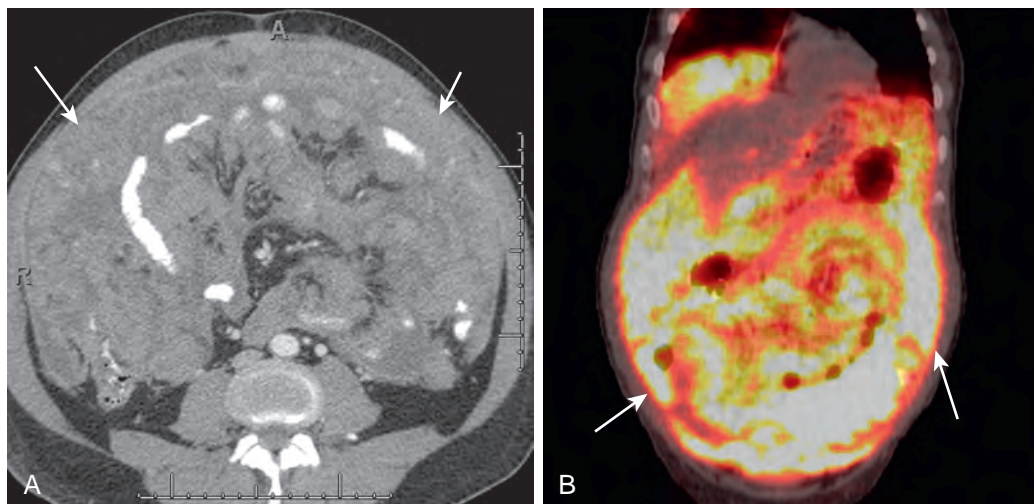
Peritoneal lymphomatosis. Axial CT (A) and coronal PET/CT (B) demonstrate peritoneal lymphomatosis (arrows). The imaging appearance is similar to that of peritoneal carcinomatosis.
